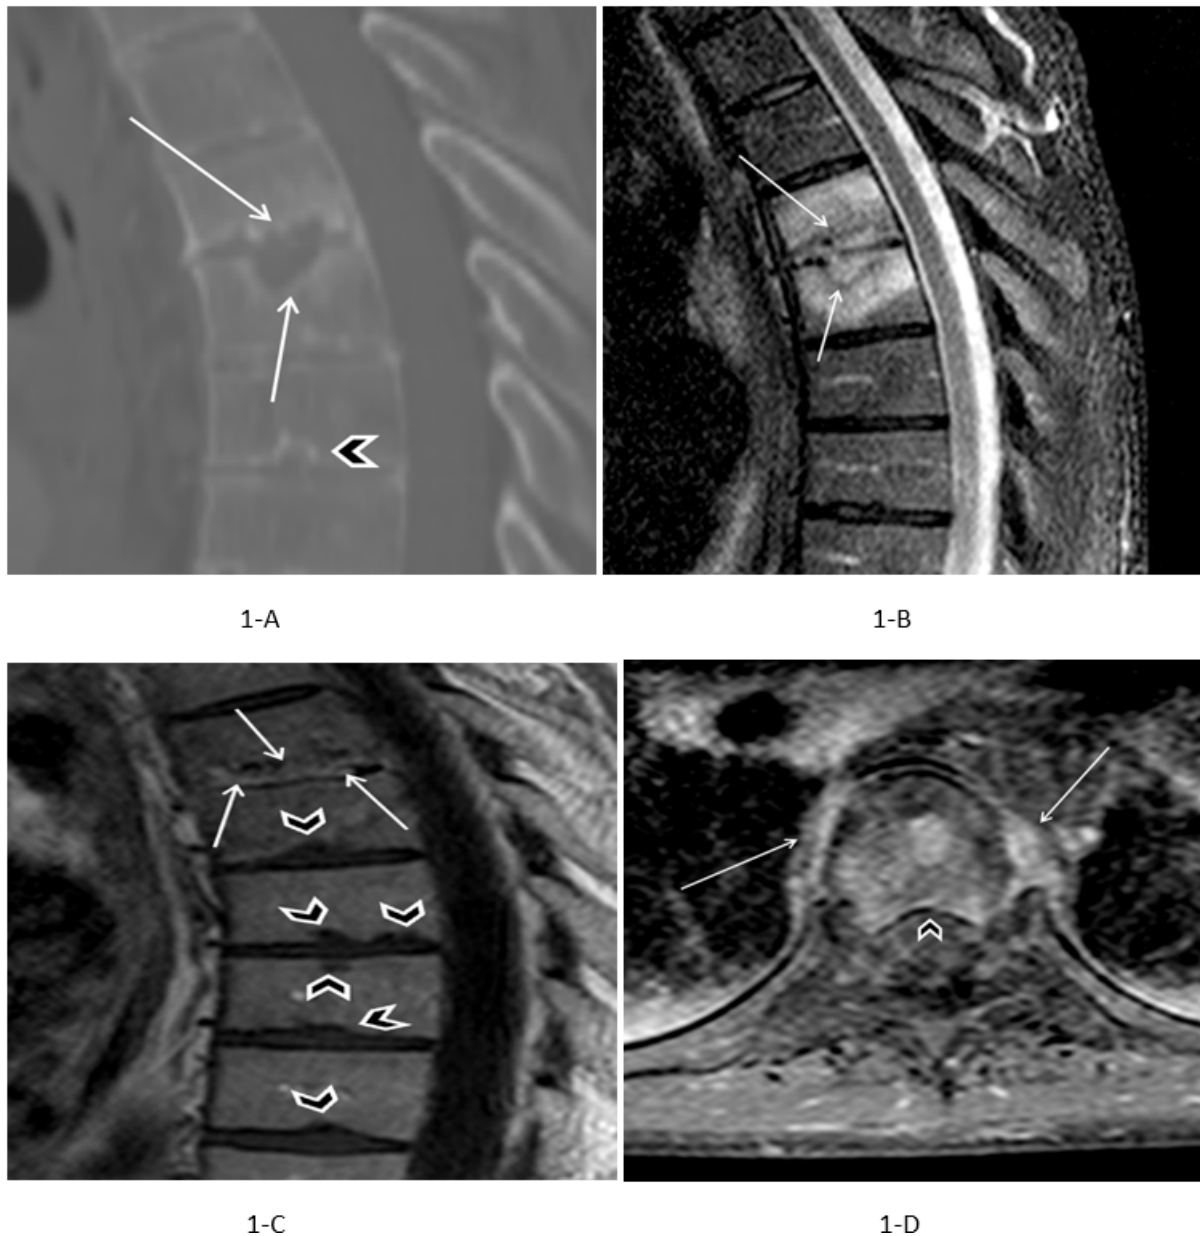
Spine CT and MRI.
